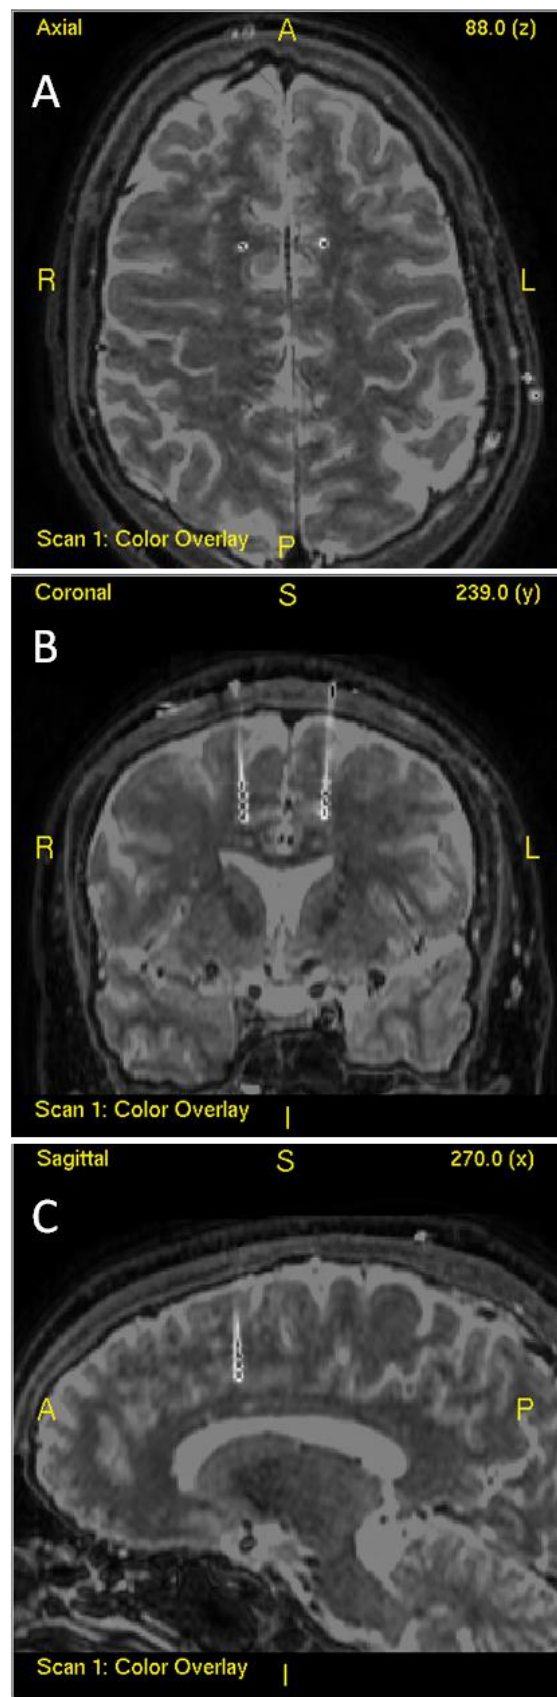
Fused MRI and CT highlighting Cg24 electrode placement (A. axial, B. coronal and C. sagittal).
